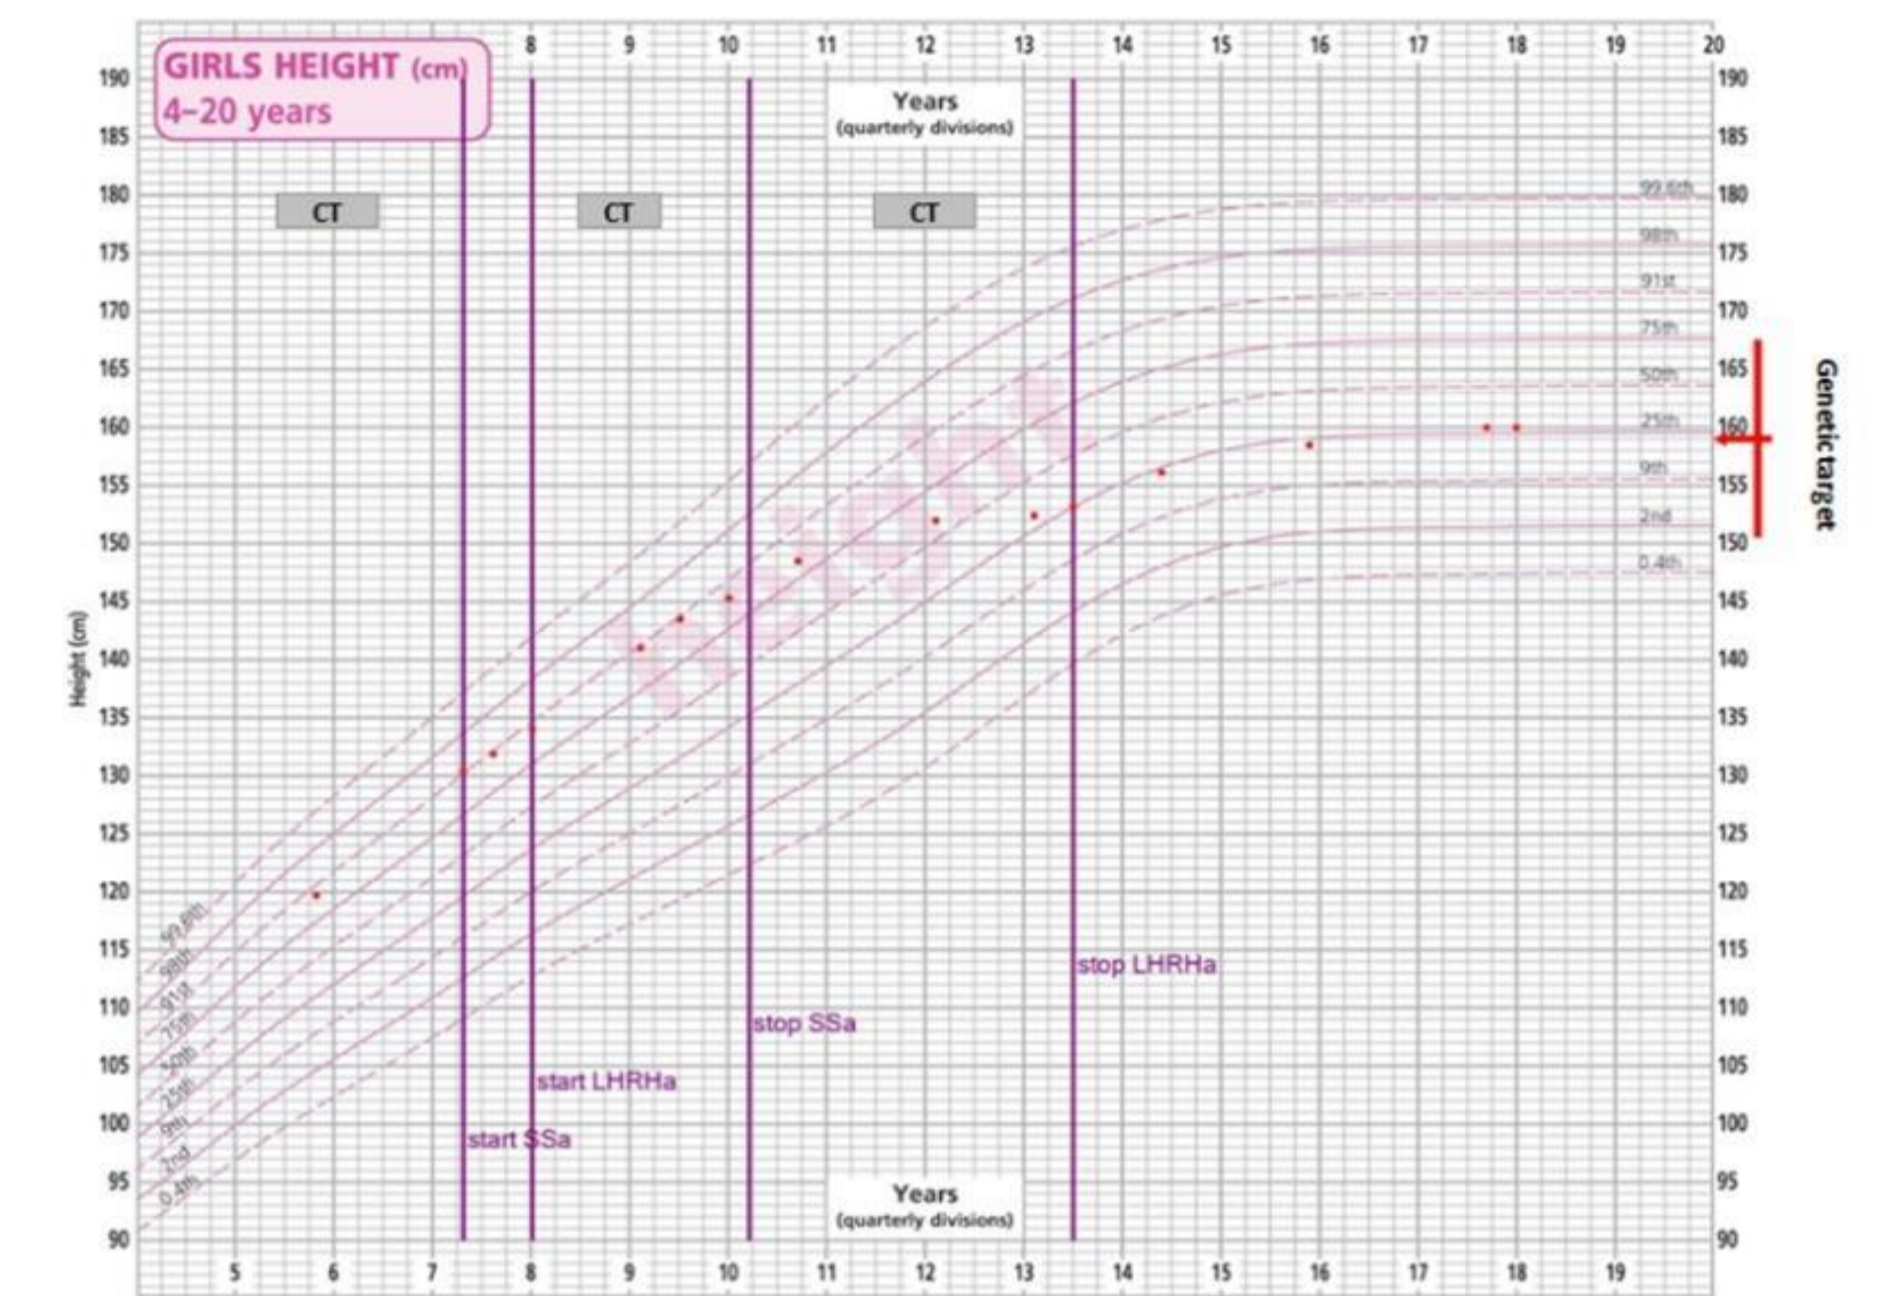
Case 1: Height chart and timing of chemotherapy (CT horizontal bars), SSa and LHRHa treatments (vertical lines)
